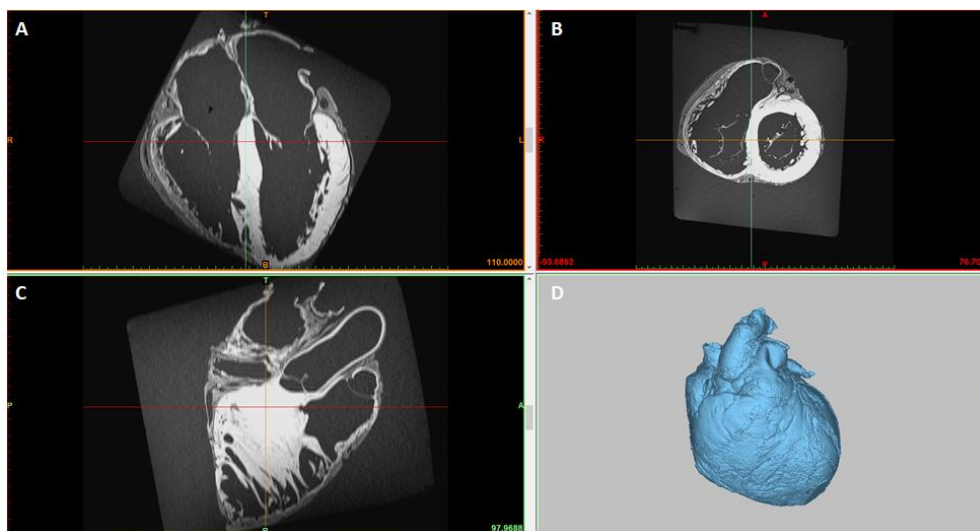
A picture of an MRI scan open in Mimics displaying the scan slices and segmentations on the three axes: (A) coronal, (B) axial, (C) and sagittal. In addition, (D) a 3D rendering, generated from the 2D segmentations, of the heart is displayed for context.
